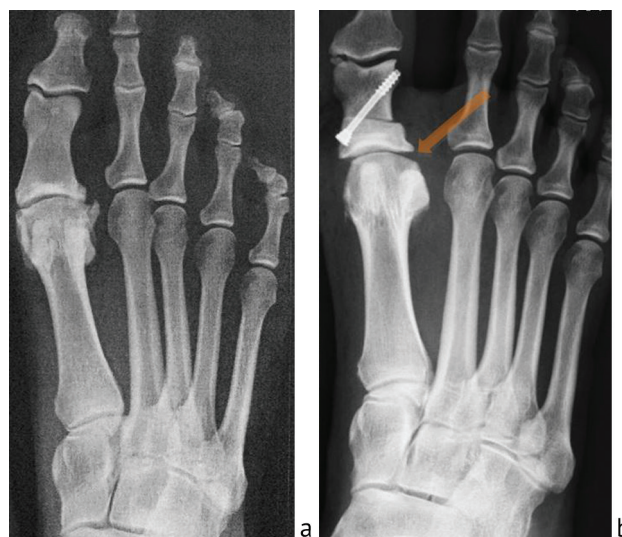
Preoperative (a) and postoperative (b) weight-bearing AP radiographs of the right foot
